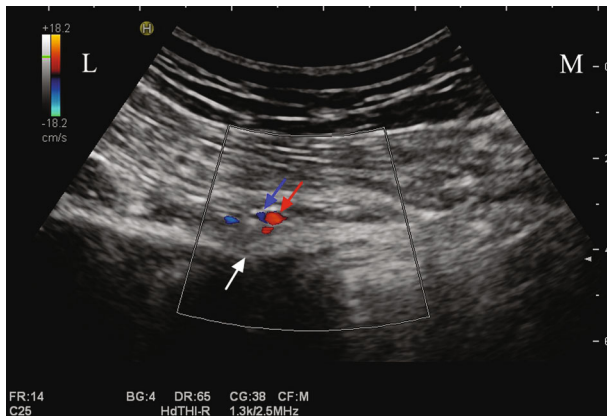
Internal pudendal artery presented in color Doppler. White arrow: ischium spine; red arrow: internal pudendal artery; blue arrow: internal pudendal vein. L: lateral; M: medial.
